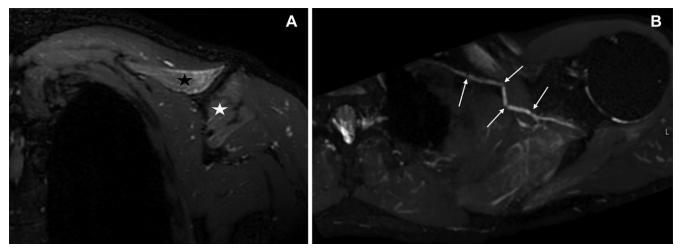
Patient 2: A 44-year-old man with Parsonage-Turner syndrome that developed 18 days following the second dose of the Moderna (mRNA-1273) COVID-19 vaccine. (A) Coronal T2-weighted fat-suppressed fast-spin echo (FSE) image 5 weeks after symptom onset demonstrates denervation edema pattern of the supraspinatus (black star) and infraspinatus (white star) muscles. (B) Oblique axial curved multiplanar reformatted T2-weighted fat suppressed FSE image demonstrates four severe intrinsic constrictions (arrows) of the suprascapular nerve.
